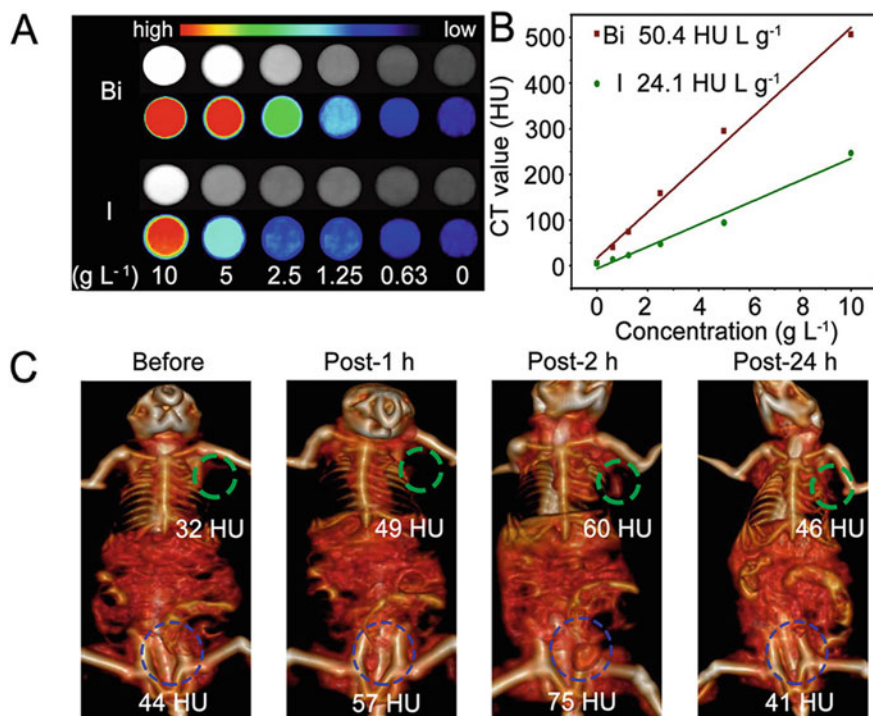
a CT images of Bi and iohexol (I) for different concentrations from 0 to 10 g L⁻¹, b Quantification of CT value for Bi–Bi₂S₃/BSA&FA NPs and iohexol samples, c In vivo CT images of tumor (green circles) and bladder (blue circles). Reproduced with permission from Ref. [58]. Copyright 2019, with permission from ACS
